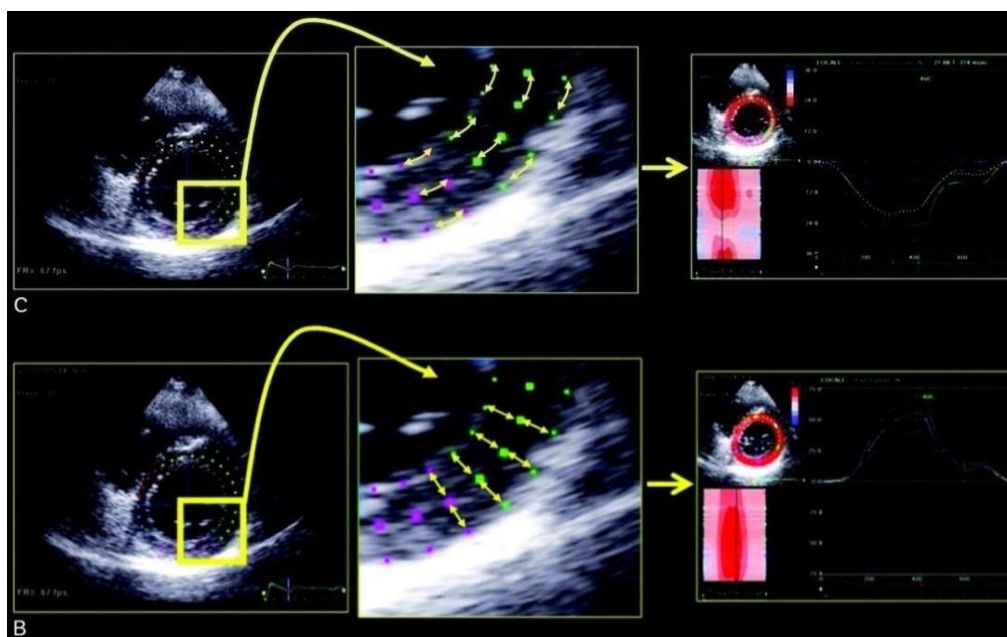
Speckle-tracking echocardiographic analysis of myocardial deformation showing measurements of radial strain and circumferential strain (52).
